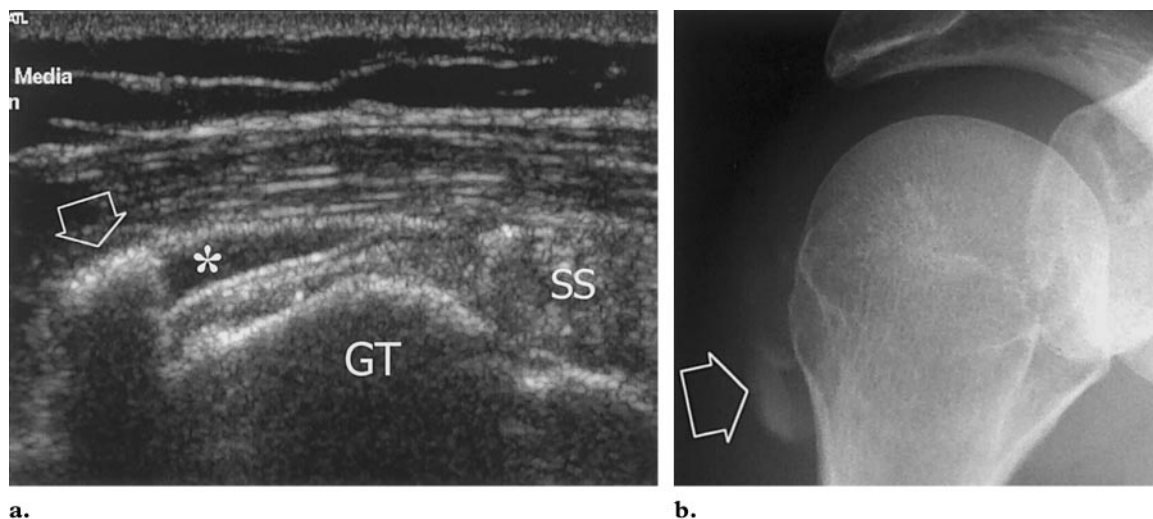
Intrabursal rupture of calcifying tendinitis in a 46-year-old woman with severe shoulder pain and tenderness. (a) Coronal 12-5-MHz US image obtained over the lateral shoulder reveals a thickened SA-SD bursa that contains fluid (*) and calcified material (arrow) just inferior to the greater tuberosity (GT) and distal to the insertion of the supraspinatus tendon (SS). (b) Corresponding radiograph shows calcified material (arrow) that lies in the dependent lateral portion of the SA-SD bursa.
